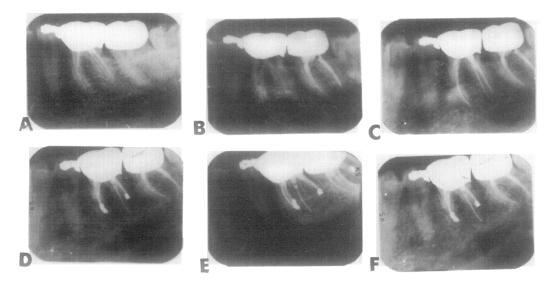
Case 2. Mandibular right first molar of 26-year-old white woman. Root canal treatment was performed by general dentist with paste technique 2 months previously. A, Preoperative radiograph of paste-filled root canal with broken instrument in mesiolingual canal. Patient has continuous pain. Mandibular right second molar is devital, symptomatic, and needs treatment. B, Radiograph shows paste removed from canals and broken file still lodged in mesiolingual canal. Third root and all four canals are located and instrumented. Unable to remove or bypass broken file; patent canal is present below blockage. Root canal treatment of mandibular right second molar is completed. C, Radiograph shows gutta-percha fillings of all four canals. Only able to fill up to broken file on mesiolingual canal. D, Patient has recurrent pain and tenderness. Surgical treatment is performed. Unable to remove piece of broken instrument on mesiolingual canals are connected by groove, slot preparation is made, and retrograde amalgam sealing both mesial canals is placed. Distal canal has paste blockage below gutta-percha filling on distal buccal root; retrograde amalgam is placed. Immediate postoperative radiograph is shown. E, Mesial view radiograph $1\frac{12}{2}$ years later shows asymptomatic tooth with bony regeneration. File in mesiolingual canal can be seen. F, Different view of recall film $1\frac{12}{2}$ years later shows asymptomatic tooth with apical bony regeneration.
